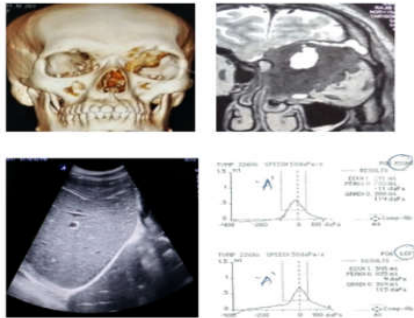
showing CT and MRI scan diagnosing fibrous dysplasia with normal USG whole abdomen and Audiometry
